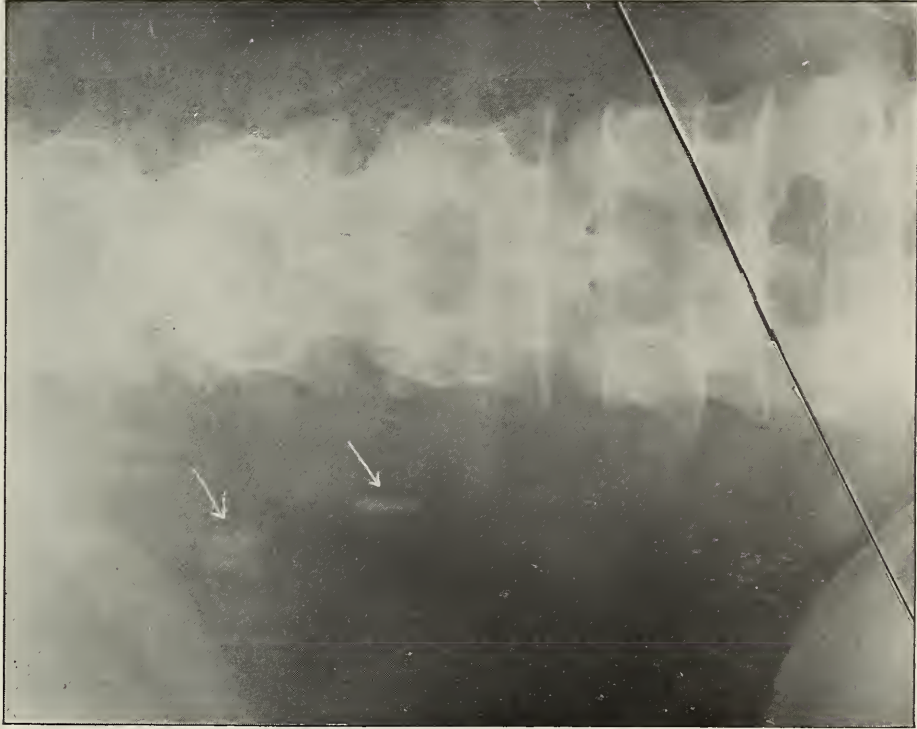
X-ray No. 13128, a. Region: right lumbar. Original plate shows two suspicious shadows. These must be studied further.
